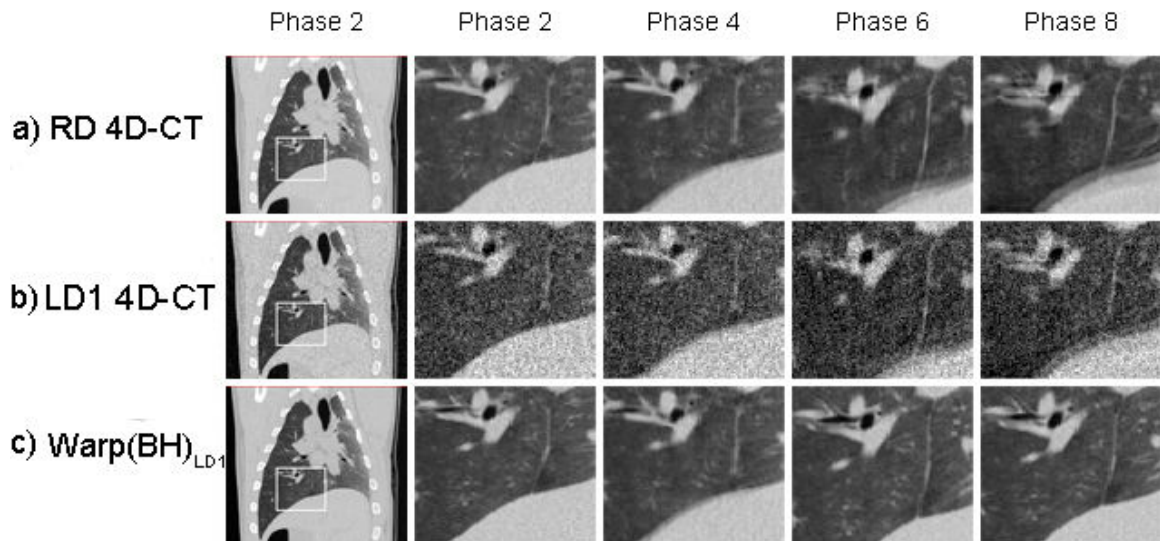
Shown are the coronal image of the a) RD 4D-CT, b) LD1 4D-CT and c) $\text{warp}(\text{BH})_{\text{LD1}}$ 4D-CT. The area outlined in the first column is expanded in the 2nd through 5th column to show the area over phases 2, 4, 6 and 8 of the breathing cycle. The $\text{warp}(\text{BH})_{\text{LD1}}$ 4D-CT is able to accurately reproduce the RD 4D-CT over the different breathing phases in spite of the extremely poor image quality of the LD1 4D-CT. Additionally, blurring artifacts present in the RD 4D-CT images are noticeably reduced.
